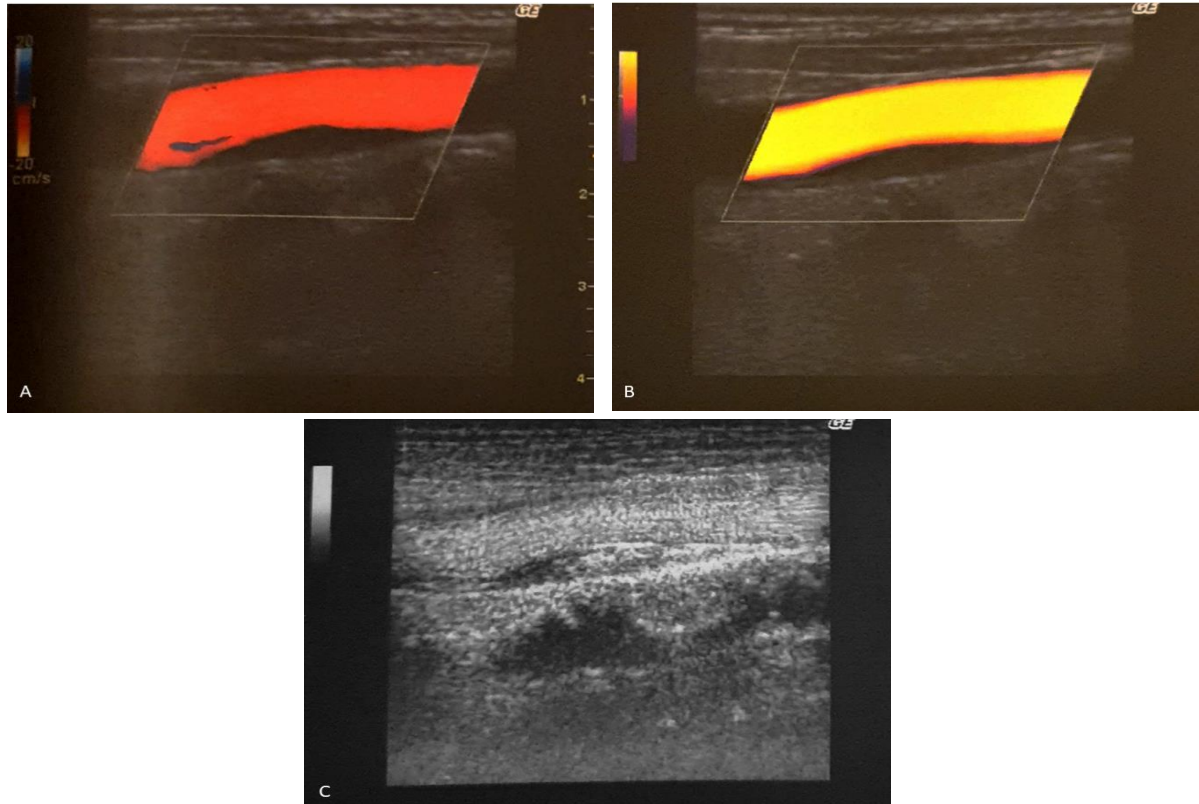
59-year-old male patient with a fibrofatty plaque in the right common carotid artery. Plaque surface delineation and morphology cannot be optimally visualized with color (A) and power Doppler (B) imaging. With B-flow imaging (C) the heterogeneous structure of the plaque and the surface delineation can be visualized.
